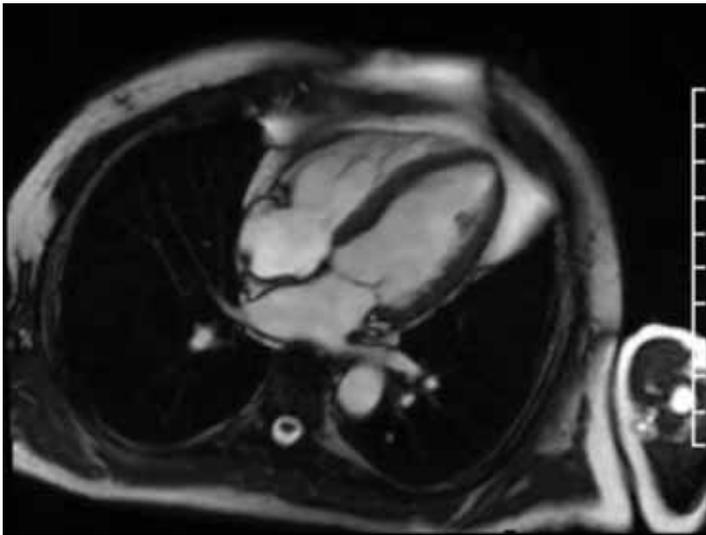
Cardiac MRI showing intracavitary left ventricular mass.
